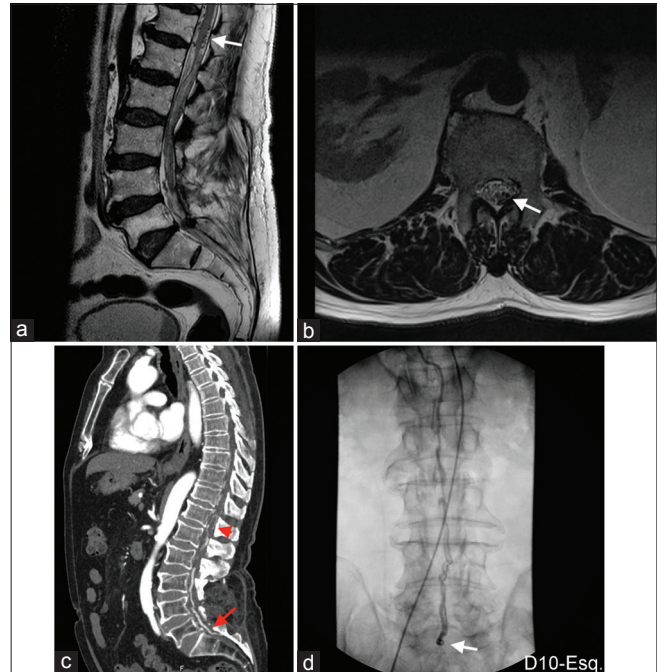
Preoperative images: (a) MRI T2 sagittal showing multiple vascular voids near conus medullaris (arrow). (b) MRI T2 axial revealing two hypointense structures on the left (arrow) that were confirmed to be the arterial feeder and draining vein of the filum terminale arteriovenous fistula (FTAVF) after the DSA. (c) CT angiogram showing the contrast enhancement of the FTAVF (arrow) and multiple vascular voids around the conus medullaris and lower spinal cord (arrow head). (d) Dorsolumbar DSA showing the FTAVF at L5-S1 (arrow) with a descending arterial feeder from left D10 and an ascending draining vein.
